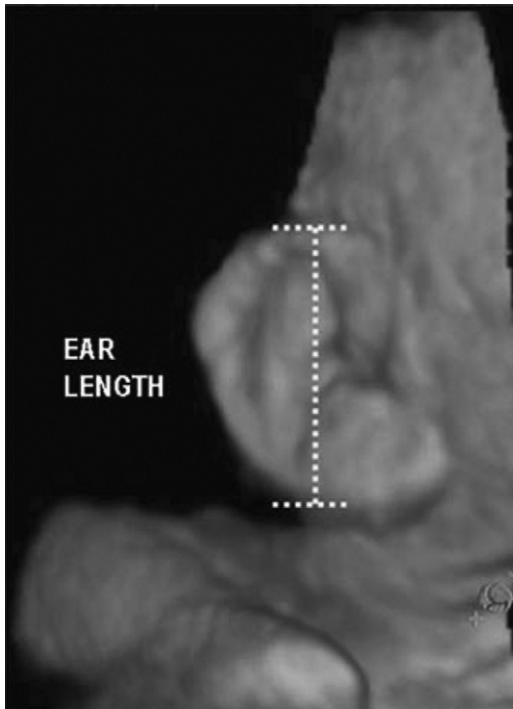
Three-dimensional ultrasound image of a fetal ear. (From Kurjak A, Miskovic B, Andonotopo W, et al: How useful is 3D and 4D US in perinatal medicine? *J Perinat Med*, 2007;35:10-27.)
